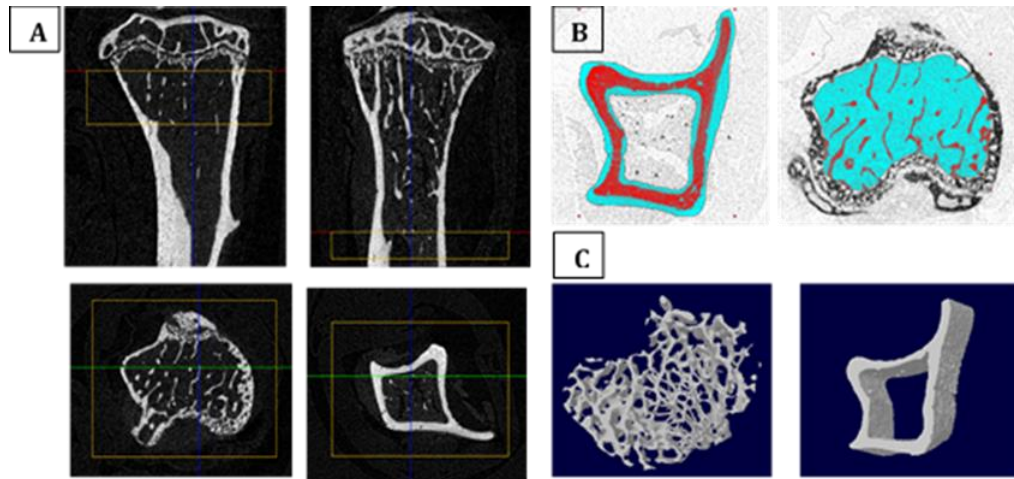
SkyScan  $\mu$ CT software used for selecting volumes for analysis: (A) Represented pictures from SkyScan Dataviewer, which were used to select the ROI (proximal tibial metaphysis [left] and proximal diaphysis [right]; (B) Manual selection of ROI using SkyScan CTAn software; (C) 3D model pictures of the trabecular bone (left) and cortical bone (right) viewed by SkyScan CTVol software.
